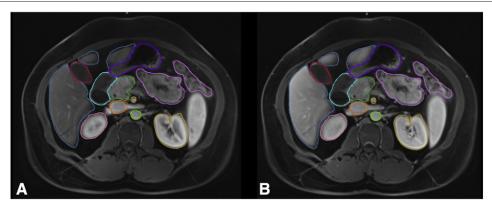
Normal pancreas case with contouring of pancreas and critical structures on T1-weighted image, precontrast (A) and arterial phase (B). Dark green: pancreatic head, turquoise: duodenum, purple: stomach, blue: liver, pink: right kidney, orange: left kidney, bright green: aorta, violet: bowel, orange: celiac axis. (Color version of figure is available online.)
